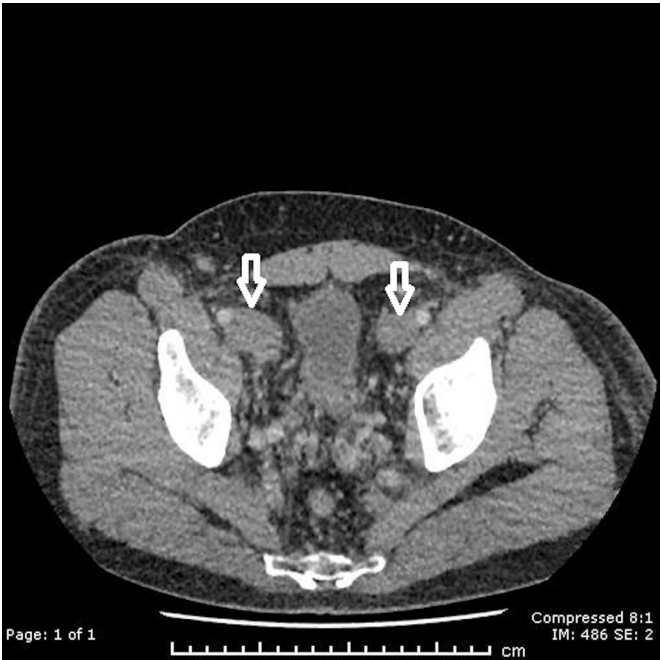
Axial CT images of the abdomen and pelvis. The white arrows indicate thrombosed iliac veins.
